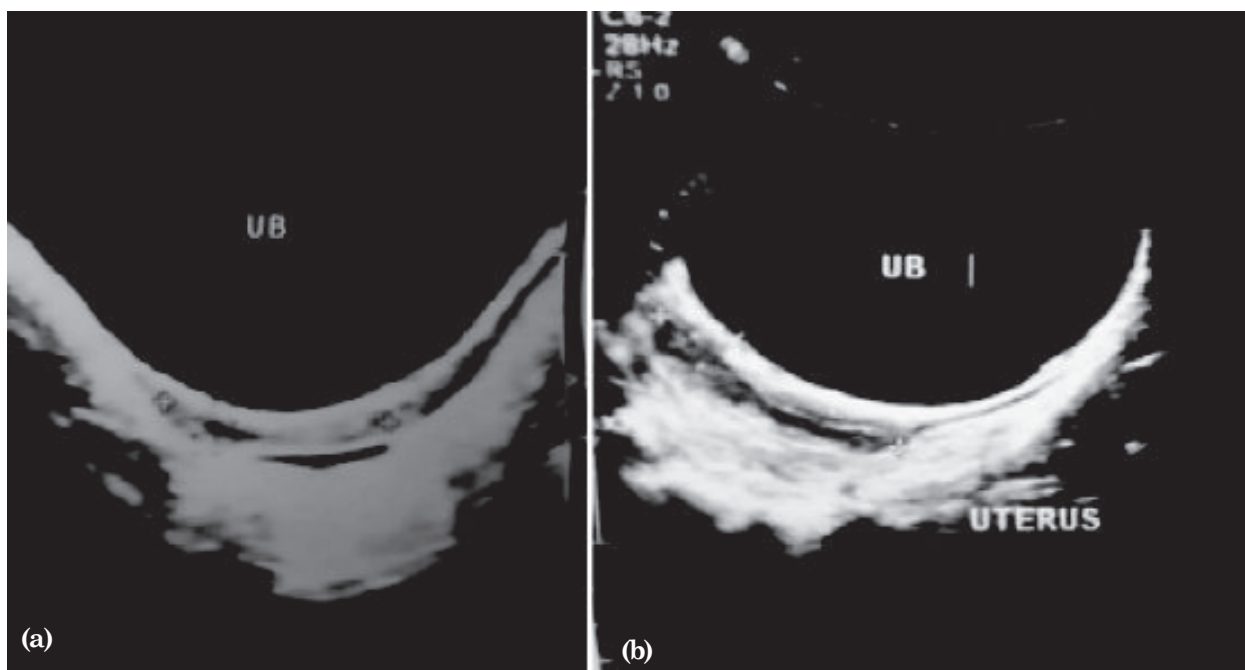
Ultrasonogram of uterus (a) during first follow up and (b) after one year
